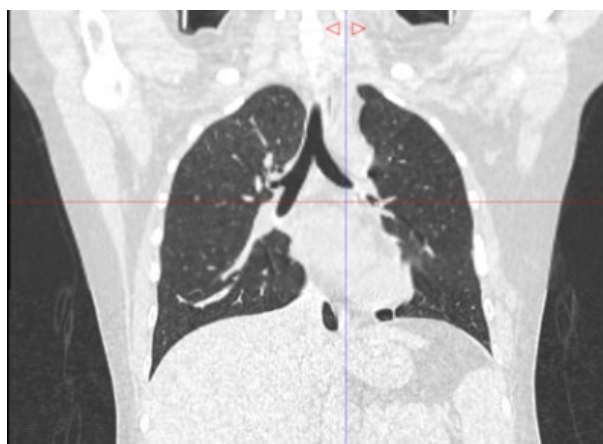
Chest CT scan of patient G. from 28/11/2023, 1 year 9 months after surgery: frontal section
